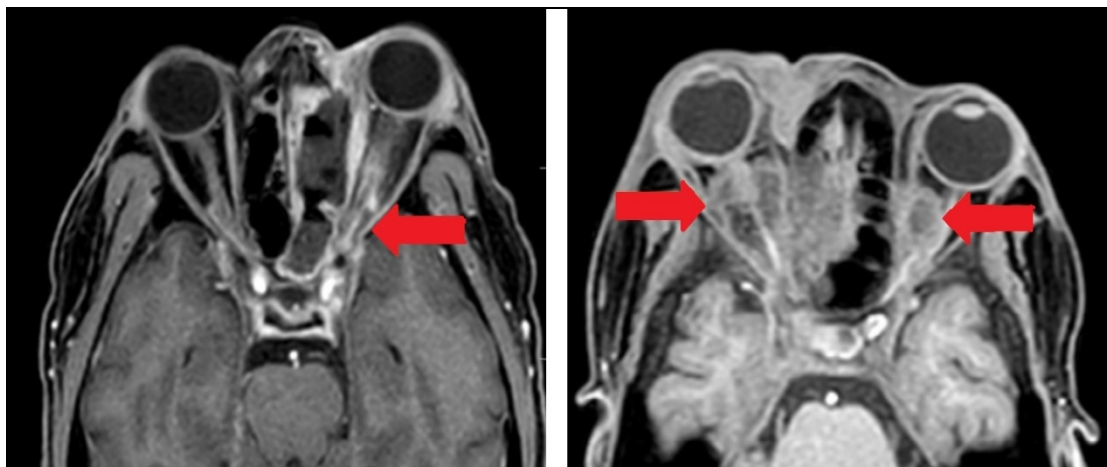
Image 1 (left side): contrast enhanced MRI image showing non-enhancing soft tissue in left orbital apex with thickened and enhancing optic nerve and proptosis. Image 2 (right side): contrast enhanced MRI image showing soft tissue enhancement in the intraconal compartment of bilateral orbits and proptosis on right side
